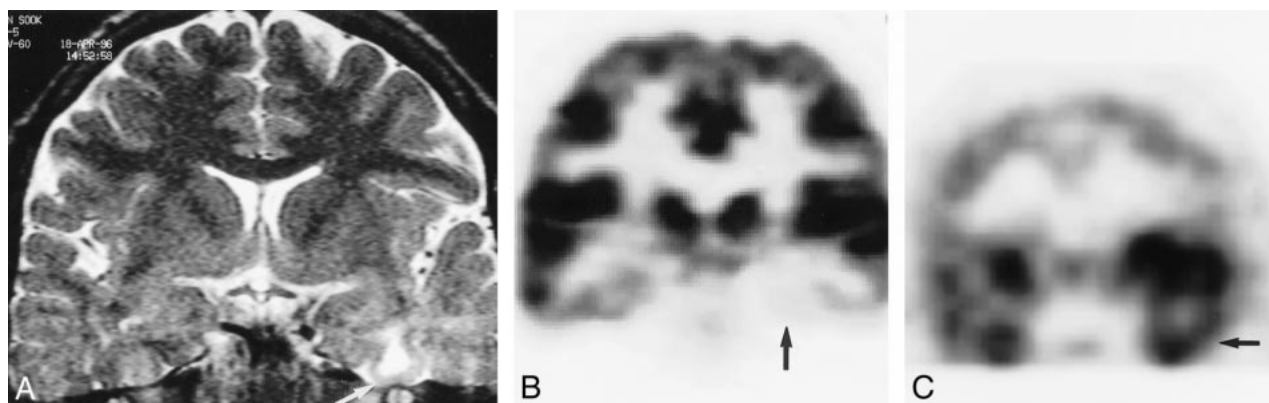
Concordance of the results among MR imaging, PET, and ictal SPECT findings for a 36-year-old man with left neocortical temporal lobe epilepsy.
